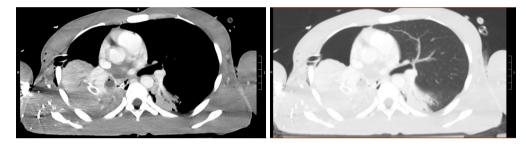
(D2816898 CT CAP from 07/05/2020). Large right pneumothorax with complete collapse of the right lung and rightward shift of the mediastinum. Fluid within the right mainstem bronchus and distal airways is suggestive of hemorrhage. A locule of air adjacent to the right mainstem bronchus raises the possibility of bronchial injury. CT, computed tomography; CAP, chest, abdomen and pelvis.
